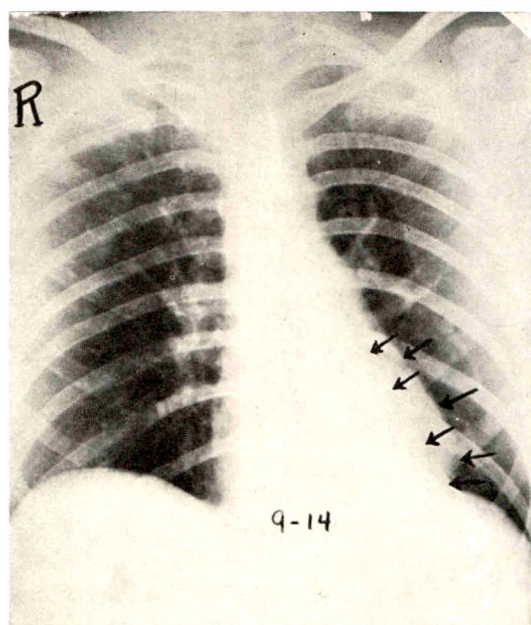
Roentgenogram of Case v taken in the anteroposterior position. A double shadow is seen to the left of the median shadow. The inner row of arrows marks the lateral border of the mediastinal pleural effusion. The outer row of arrows marks the lateral heart border. Note the characteristic triangular shape of the encapsulation.
